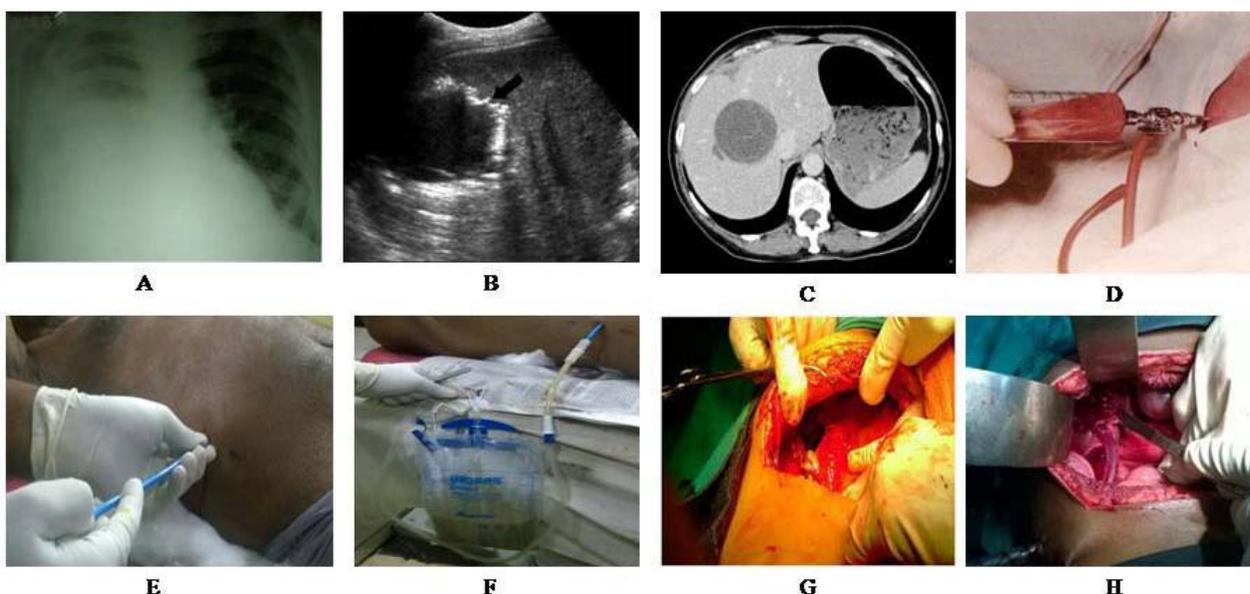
Findings of liver abscess and invasive treatment management [A] Chest X-Ray showing elevated right hemidiaphragm with pleural effusion; [B] Abdominal USG showing single abscess cavity; [C] Abdominal CT scan showing single abscess cavity; [D] Image guided percutaneous aspiration; [E] Image guided Pigtail drainage; [F] Image guided pigtail catheter drainage; [G] Open surgical drainage: showing abscess cavity; [H] Open surgical drainage: drain in abscess cavity
